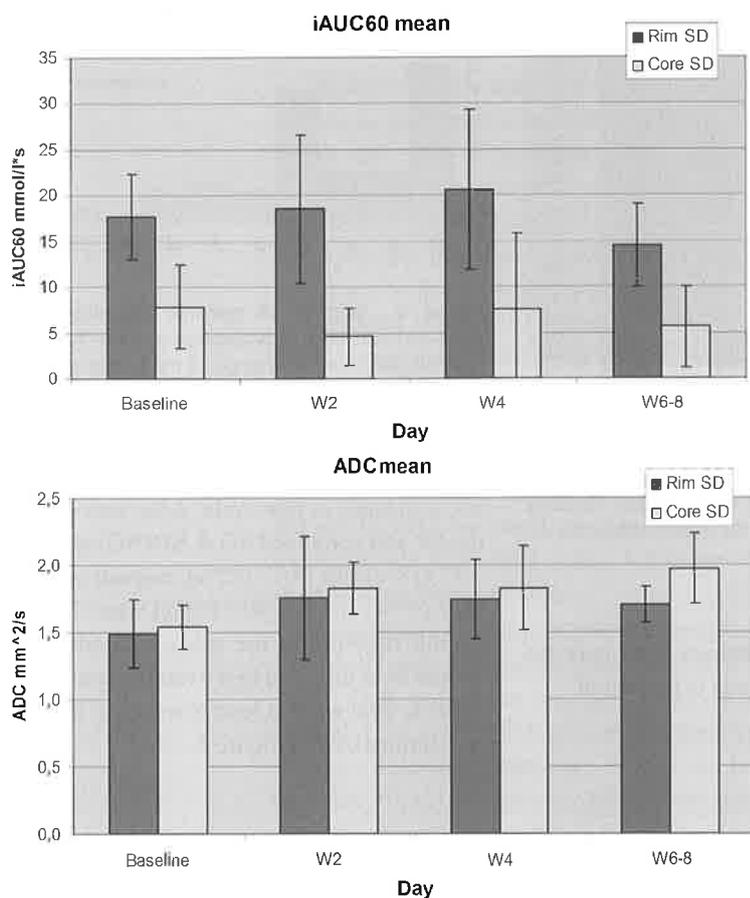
MRI parameter comparison. Comparison of mean iAUC60 and ADC values over the various time points for lesion rim and lesion core. While there are larger differences between rim and core for iAUC60, the ADC values show only minor differences.
